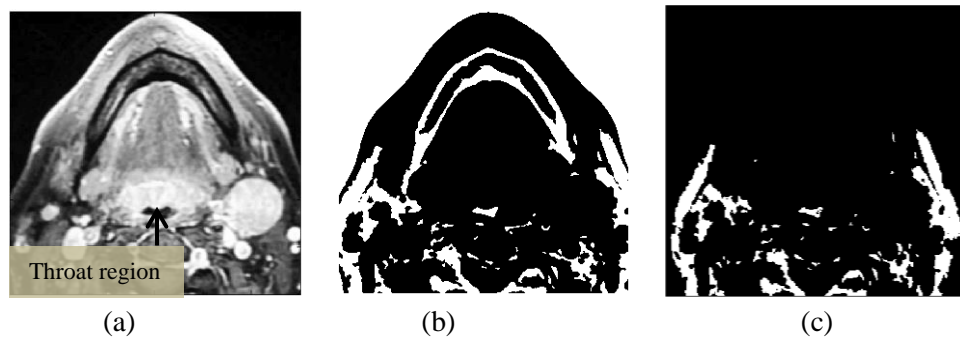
Initial steps for a throat region detection (a) MRI slice $I(x, y)$ (b) binary image $K(x, y)$ (c) binary image $K(x, y)$ after removal of connected components with maximum signature radius greater than a certain value.
